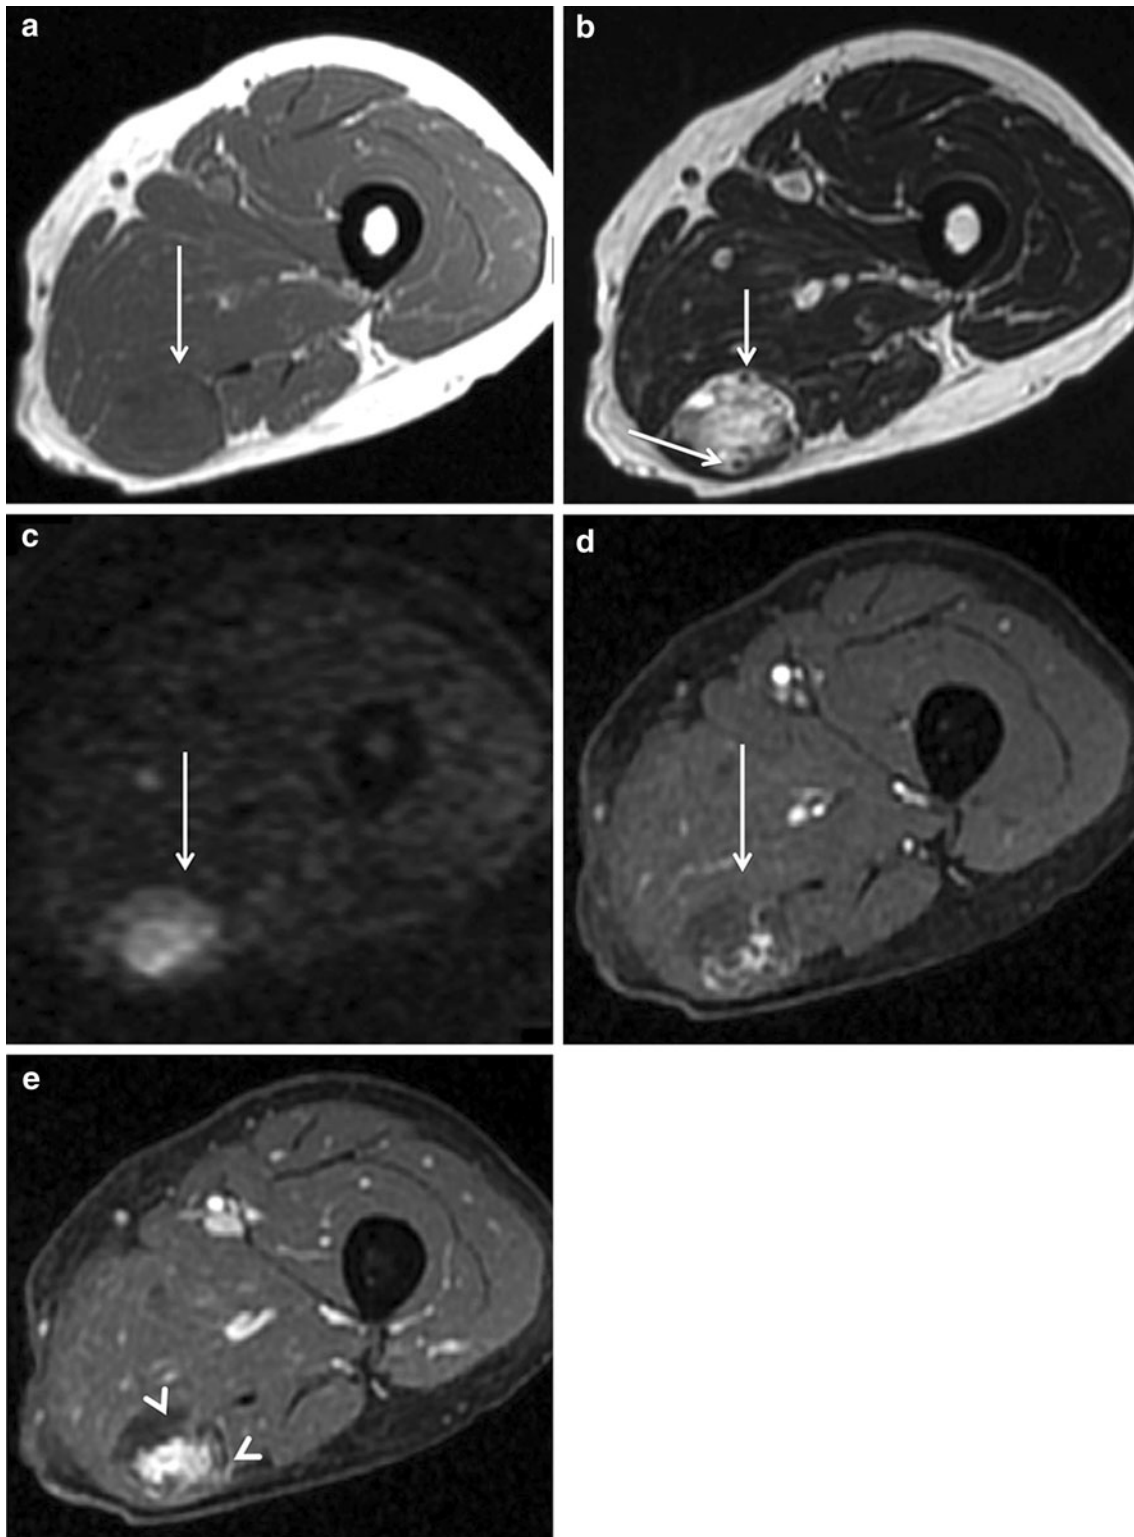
Angiosarcoma of soft tissue in a 50-year-old female in the thigh. a Axial T1-weighted MR image shows a well-defined mass in the hamstring, isointense to muscle (*arrow*). b Axial T2-weighted MR image shows a heterogeneous signal with flow voids (*arrows*).
